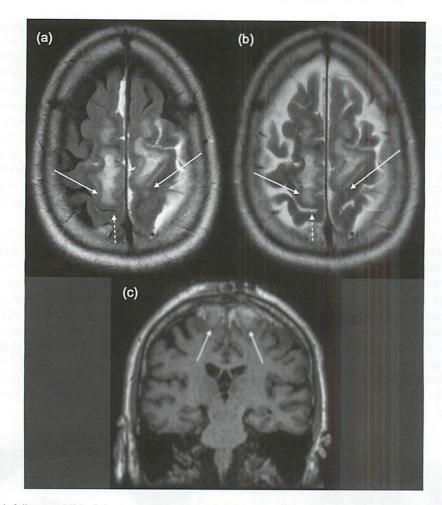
Two-week follow-up MRI of the brain. (a) An axial FLAIR image of the superior frontal and parietal brain shows FLAIR hyperintense contusion in the bilateral frontal lobe precentral gyri (solid arrows) with extension into the posterior aspect of the bilateral superior frontal gyri in the region of the supplementary motor areas. A dotted arrow indicates the central sulcus confirming that these contusions affect the precentral gyri in the region of the lower extremity motor cortices. (b) An axial T2 image shows the same findings (c) A coronal T1 image demonstrates T1 hyperintense hemorrhagic contusion within the bilateral frontal lobe precentral gyri (solid arrows). Hyperintense subarachnoid and subdural hemorrhages are also present in images (a–c).
